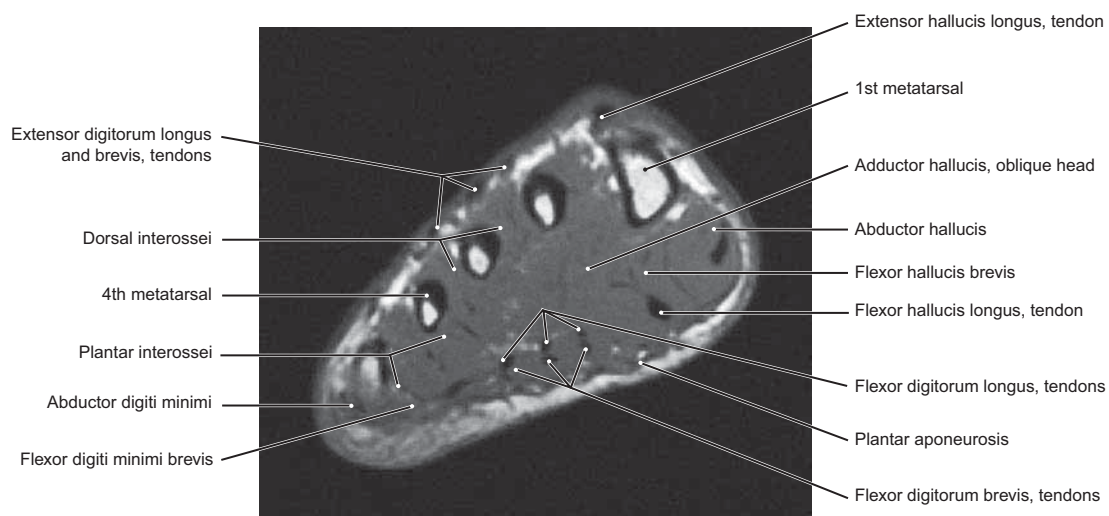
MRI through the Metatarsal Bones of the Right Foot
